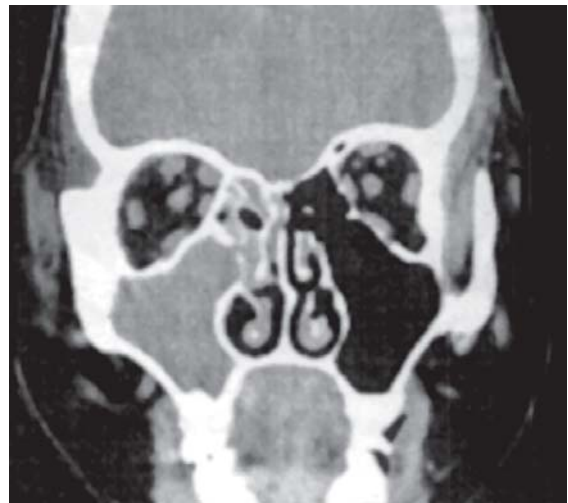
CT scan cut at the level of orbit
